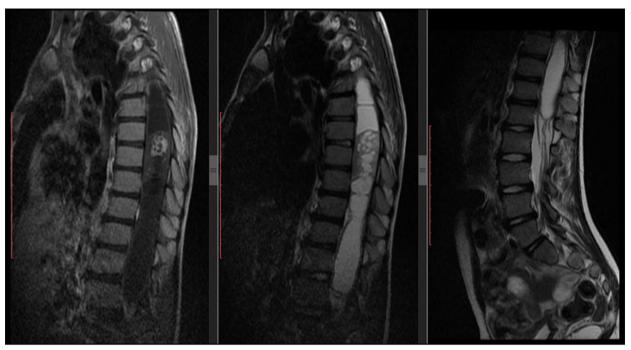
A 9-year-old female was referred to our Emergency Department with urinary retention, difficulty breathing, low back and left leg pain, numbness, and weakness. Preoperative T1-weighted MRI demonstrated hyperintense areas, T2-weighted MRI showed an iso-hyperintense irregular diffuse intradural intramedullary thoracic lesion with several septae, measuring 24×33×6 mm at T8–T10 level. The lesion up and down side syrinx cavities extends from C5 to L1 levels.
